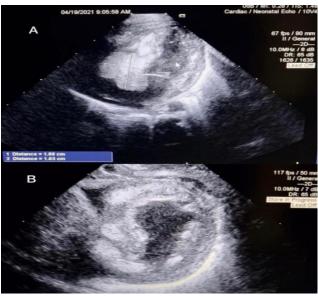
Echocardiography images of cardiac rhabdomyoma. Four chamber view showing a portion of the mass measuring 18mm x16mm, occupying almost all of the right ventricle (RV). Figure-1B: Parasternal short axis view at the mid left ventricle (LV) level showing the myocardium studded with multiple masses.
